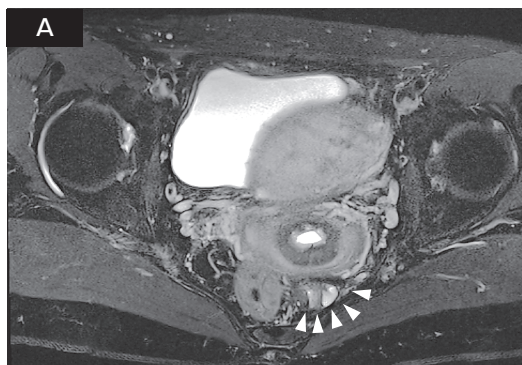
MRI T2-weighted images show a low-signal intensity lesion with an internal high-signal intensity area on the anterior sacral surface, but communication with the rectum is not evident. A, horizontal section; B, sagittal section. Red triangles indicate the cystic lesion.
